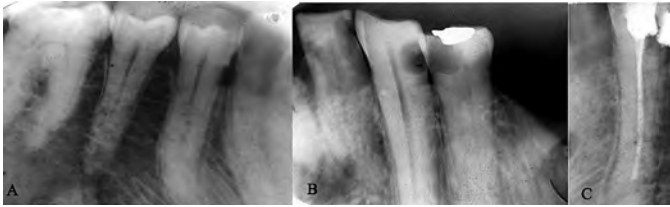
(Left) Mandibular left second premolar. (Center) Mandibular right second premolar of the same case (diagnostic radiograph). (Right) Postoperative mandibular right second premolar showing two roots. Case is a 45 year old female.
